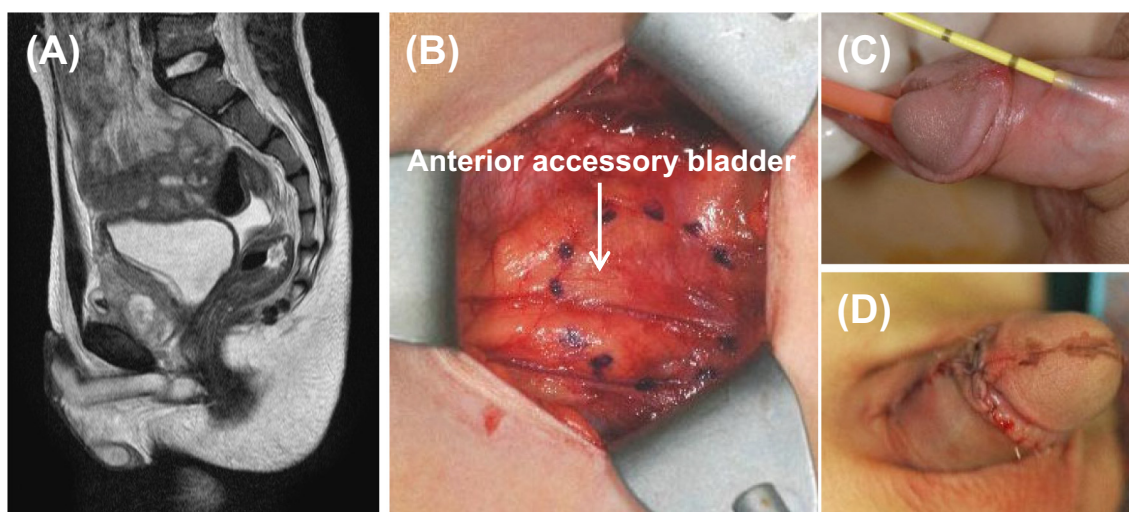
Case 12 (type III). (A) A magnetic resonance image showing the presence of an anterior accessory bladder. (B) An intraoperative image showing the use of the transpubic approach. (C) External anatomy of the opening of the dorsal urethra. (D) Surgical outcome after the excision of the anterior bladder and dorsal urethra.
